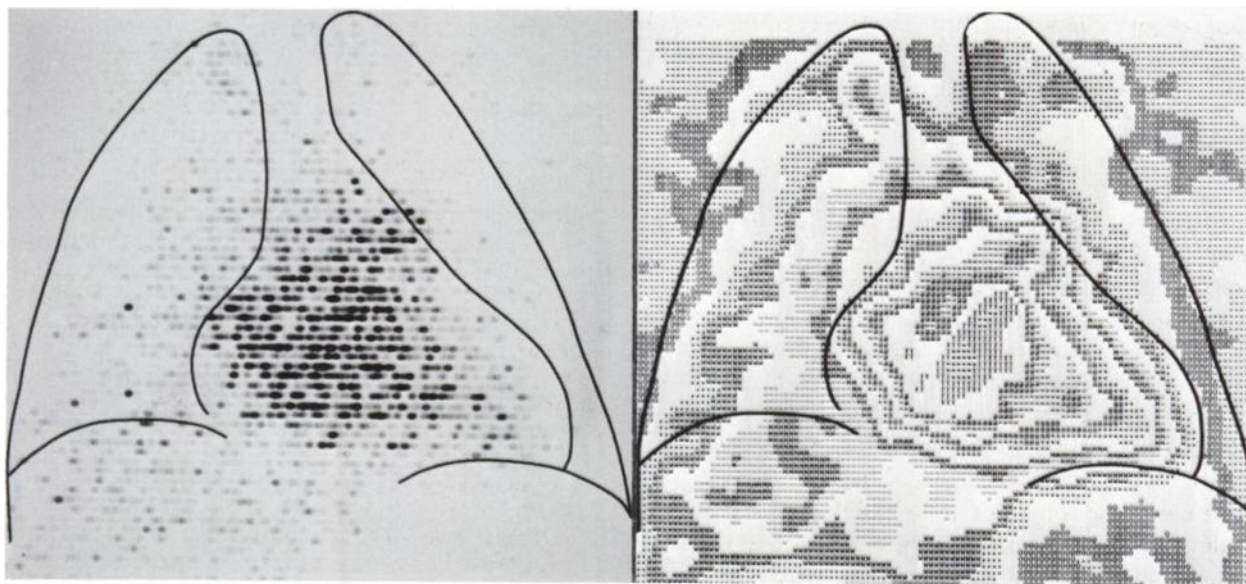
Photoscan of heart (left) after injection of ^{131}I human serum albumin is registered against tracing made from parallax-free roentgenogram of chest. While most activity lies within heart shadow, no notion of counting rate is possible and little detail
